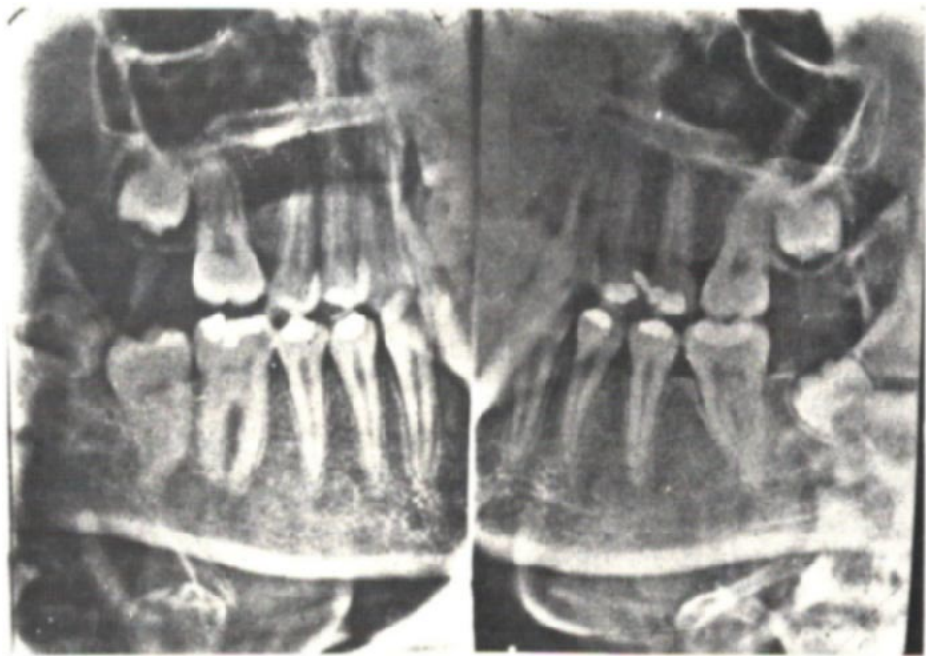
Follow-up radiograph showing lower right third molar developing.
